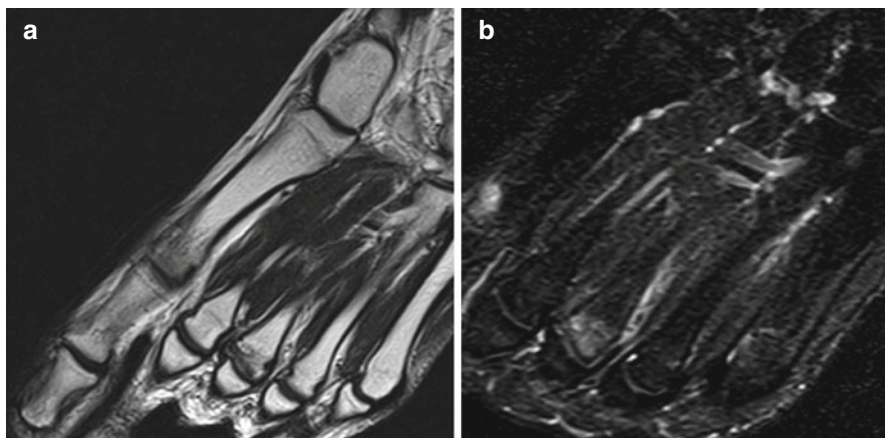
MRI coronal oblique (a–b) plains show signal alteration on the third metatarsal head, suggestive of Freiberg disease
